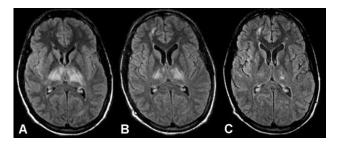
Time course of the bithalamic edema in magnetic resonance imaging, fluid attenuated inversion recovery sequences, repetition time = 9,000, and echo time = 110. Small areas of high signal intensity in the right frontal lobe indicate postcontusional damage, as already seen on the corresponding computed tomographic scans. (A) Magnetic resonance imaging on day 21 after admission shows hyperintense bithalamic edema, corresponding to the computed tomographic scan in figure 1C, which led to further imaging. Follow-up magnetic resonance imaging on day 27 (B) and day 40 (C) show a visible reduction in the size of the edema, matching the clinical restitution.
